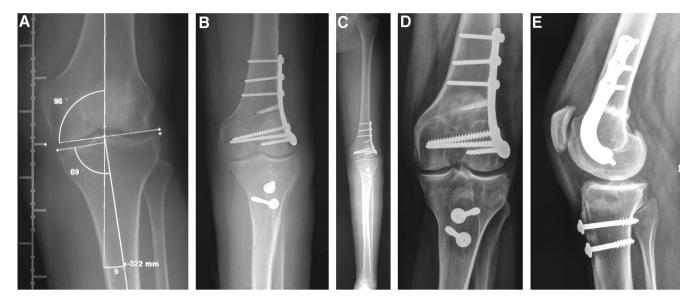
A. Stage 1 lateral compartment osteoarthritis of the knee associated with patellofemoral osteoarthritis. HKA angle of 189°, mechanical medial distal femoral angle of 98° and mechanical medial proximal tibial angle of 89°. B. Computer-assisted lateral opening femoral varus osteotomy with a tricalcium phosphate wedge and OTIS-F® plate, along with tibial tubercle medialization and iliotibial band piecrust lengthening. C. Post-operative long-leg standing radiograph showing valgus correction. D and E. X-ravs one year post-operative: Lysholm-Tegner score of 90.
